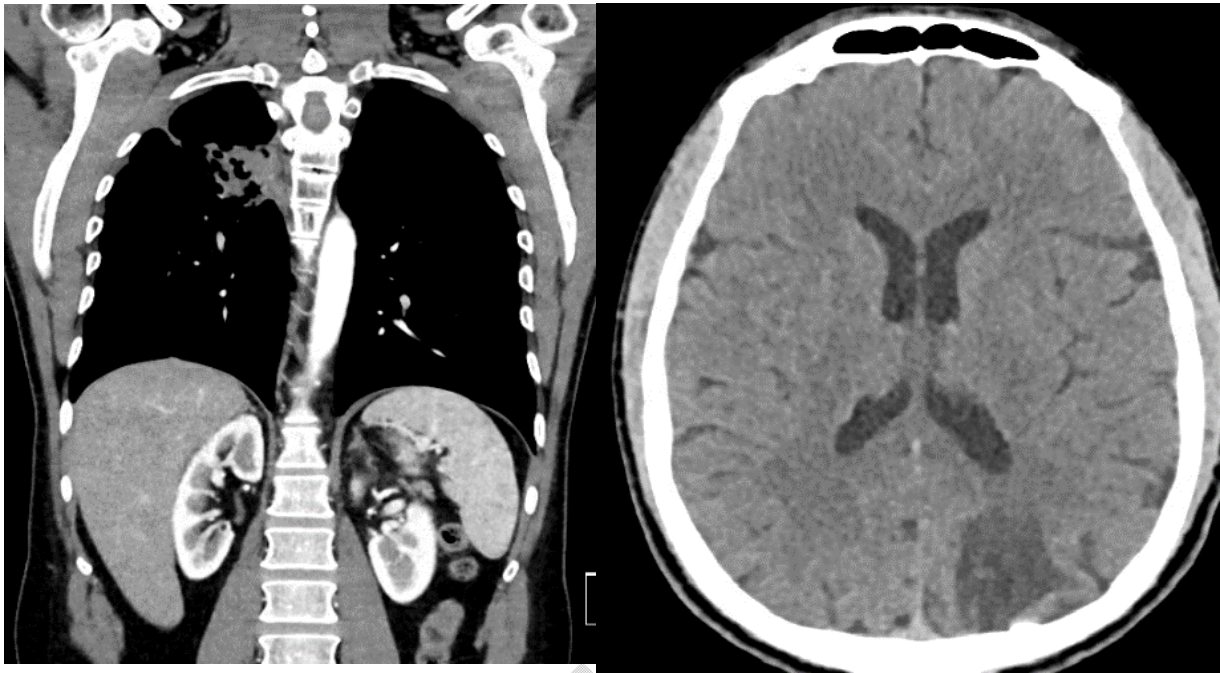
CT scan of the head and body conducted in 2020
